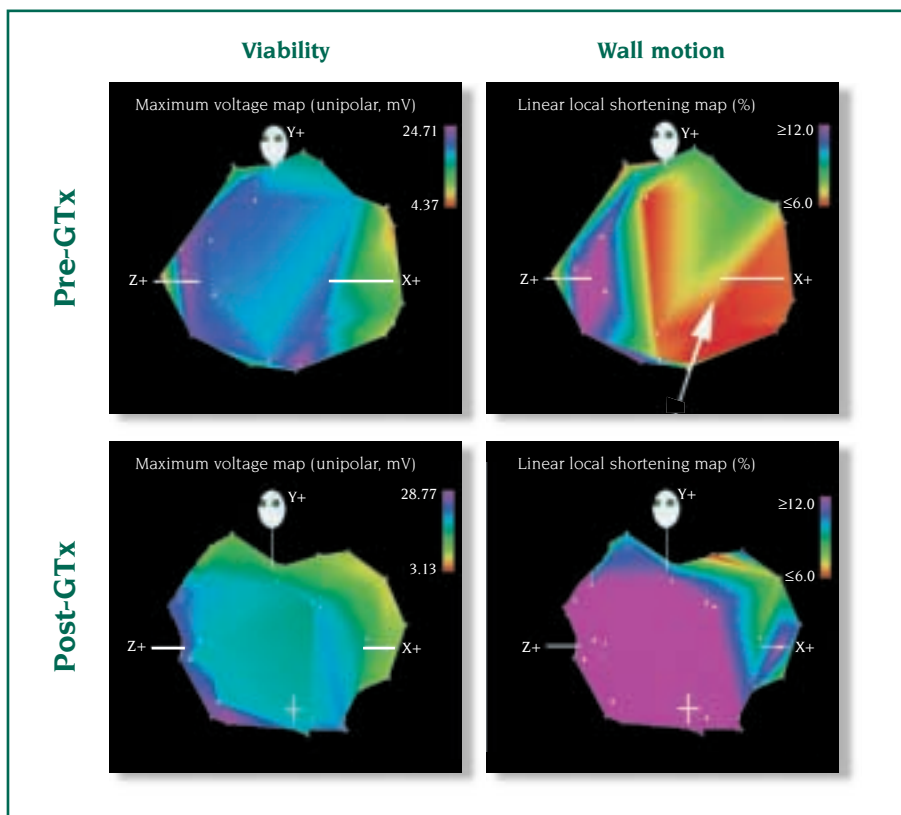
NOGA™ left ventricular (LV) electromechanical mapping (EMM). UpV and linear local shortening (LLS) NOGA™ images in the left anterior oblique (LAO) projection (upper left and right panels, respectively) of a 53-year-old male prior to plasmid DNA encoding the 165-amino-acid isoform of human vascular endothelial growth factor gene transfer (phVEGF₁₆₅ GTx) showing an area of electromechanical uncoupling suggestive of ischemic or hibernating myocardium that involves the inferolateral region (arrow). Sixty days following GTx, Unipolar voltage (UpV) and LLS images (lower left and right panels, respectively) show complete resolution of ischemia (1.39 cm² pre-GTx vs 0.00 cm² post-GTx) that corresponds to changes observed on single photon emission computed tomography (SPECT) scan (see Figure 8).
